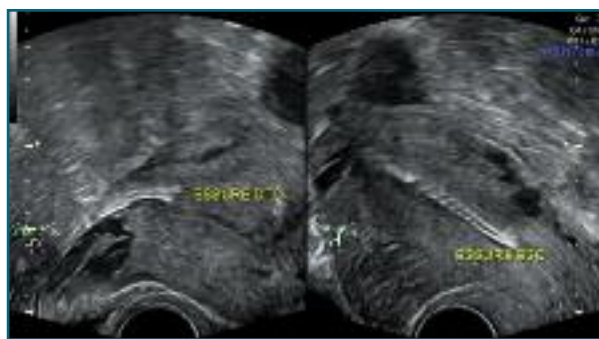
Transvaginal ultrasound – right Essure® well positioned (transverse plane of the uterus); Left Essure® in intracavity position (longitudinal plane of the uterus).
